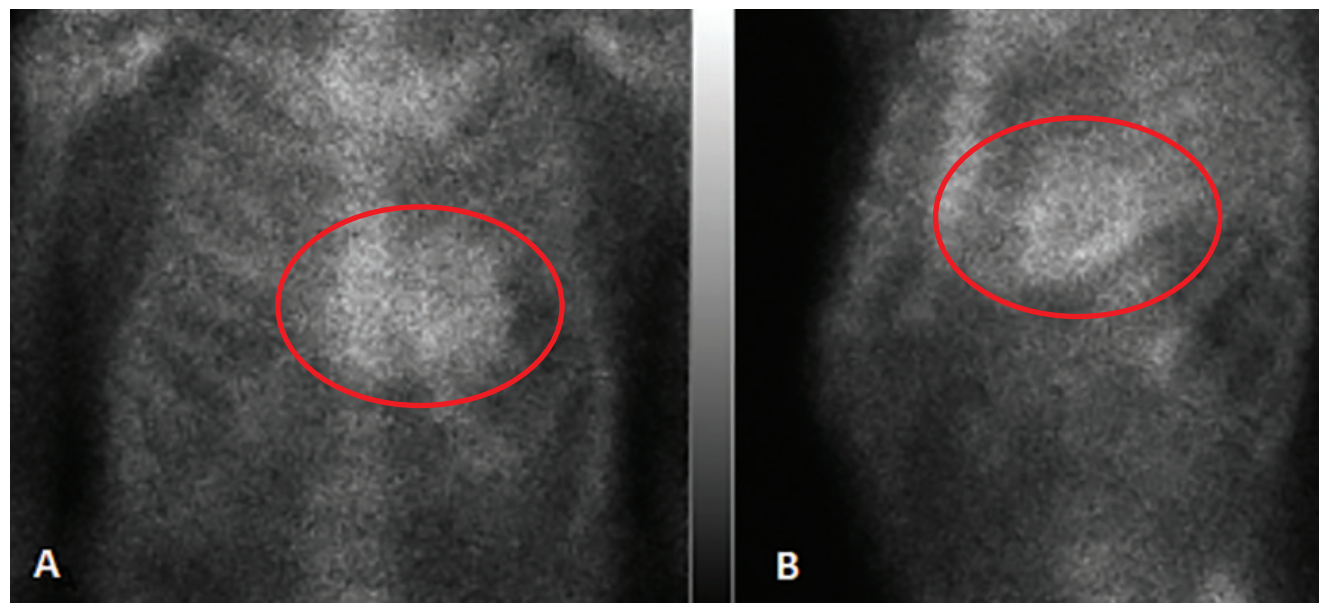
Technetium-99m pyrophosphate scintigraphy. (A) Anterior and (B) left anterior oblique views in our patient demonstrated grade 2 to 3 myocardial uptake of the radiotracer (circles) 3 hours after injection, thus meeting diagnostic criteria for transthyretin amyloid cardiomyopathy.
